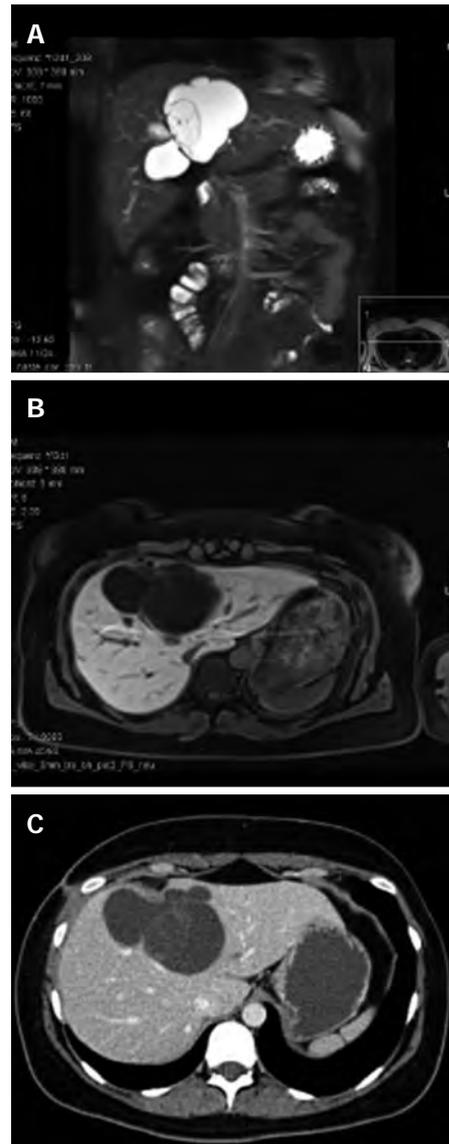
Radiographic images of the central liver cyst. Magnetic resonance imaging (MRI) demonstrated a well-defined lobulated cystic lesion without enhancement after administration of liver-specific contrast material (gadoteric acid) in the arterial, venous or delayed phase. A: MRI, T2, coronary reconstruction; B: MRI, T1, transversal; C: Contrast-enhanced computed tomography scan, transversal.
